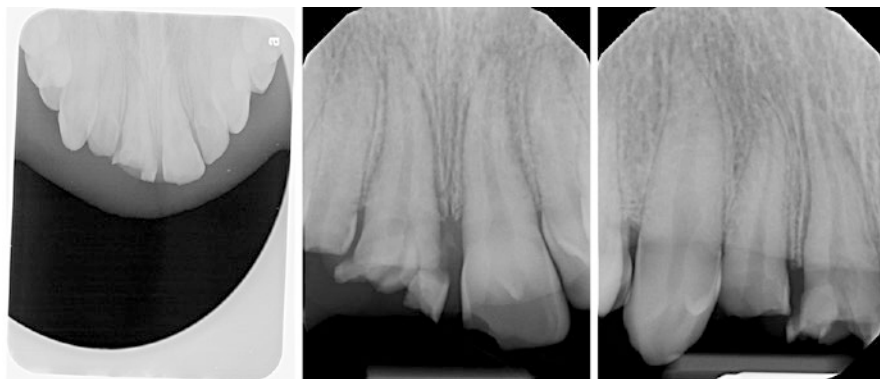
These radiographs were taken immediately after this teenager suffered a dental trauma, injuring his right-hand-side permanent maxillary lateral incisor and both his central incisors. An attempt was made to take a true maxillary occlusal, but a lot of useless radiation was aimed at his chest. More accurate periapical radiographs were subsequently obtained using a solid-state sensor. One can appreciate the widened periodontal ligament space around the right-hand-side central incisor, indicating that the impact on that tooth must have been tremendous. The shattered tooth crown is evidence of that. The occlusal radiograph should have been taken more carefully though (see Chap. 3)
